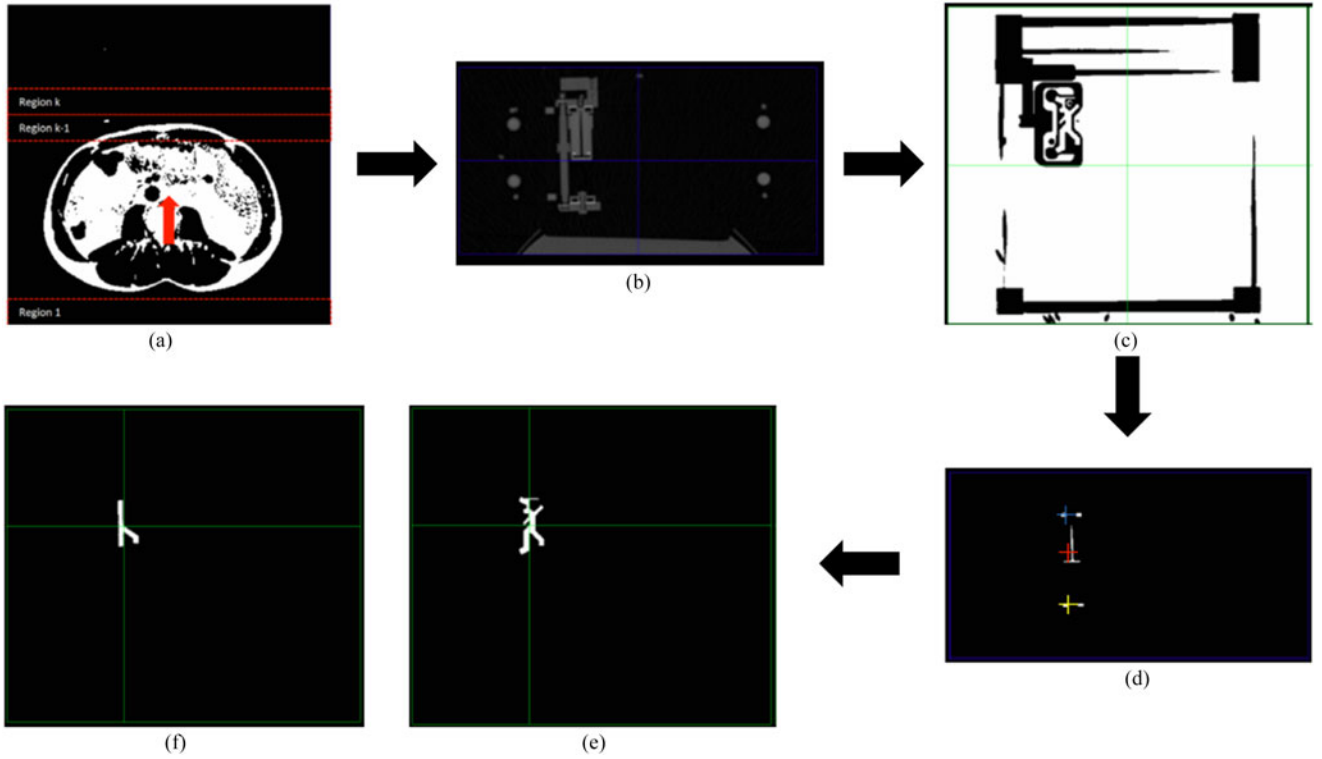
Image processing steps used for automatically segmenting the fiducials from the CT images. (a) Patient anatomy is cropped by finding the top of the patient's body using a rectangular region of interest scanned from bottom to top. (b) Transverse cut of a CT image showing the cropped result. (c) Coronal cut showing the thresholded robot. (d) Volume-thresholded image showing three separate connected components with their centers marked with crosses. Coronal cut showing the resulting segmented upper (e) and lower (f) fiducials.
